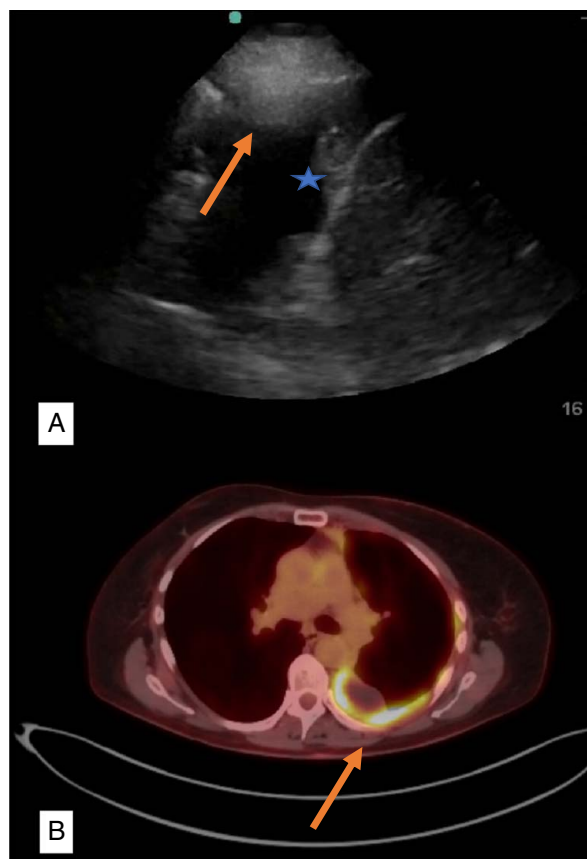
(A) Ultrasound of a patient with a malignant pleural effusion demonstrating pleural-based masses (star) and pleural thickening (arrow). (B) Corresponding PET CT confirms diffuse FDG-avid parietal pleural thickening (arrow).
